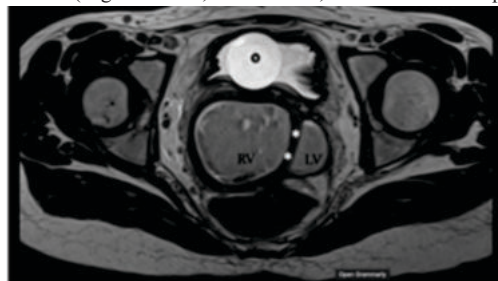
Non contrast axial T2 weighted MRI image showing right obstructed hemivagina (RV) and left patent vagina (LV) with an isointense vaginal septum (*)
